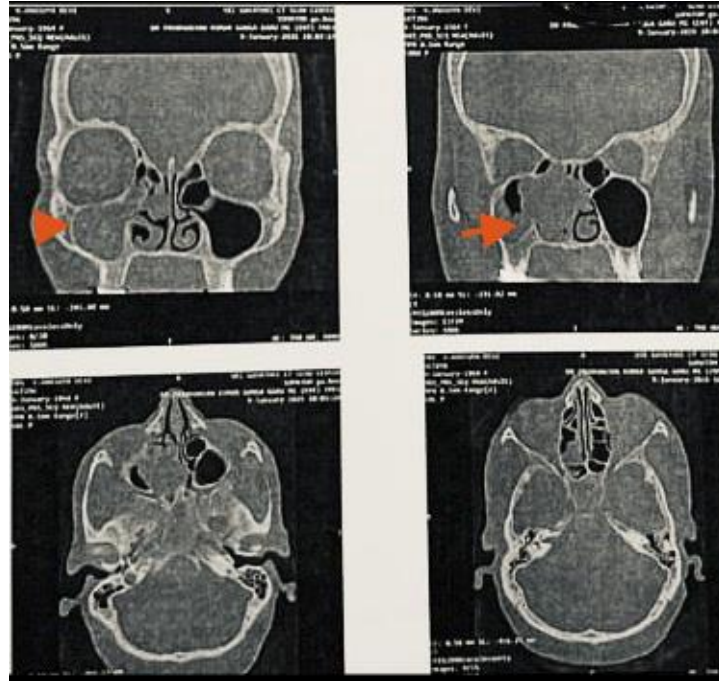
CT PNS showing right nasal polyposis with mass effect on the medial wall of right maxillary sinus and posterior 1/3rd nasal septum
